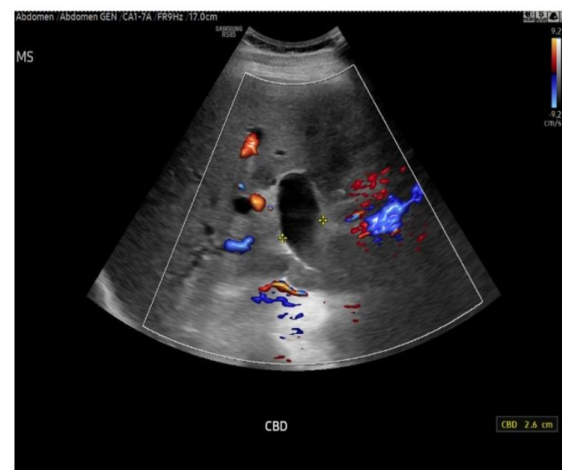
RUQ ultrasound showing common bile duct dilation
